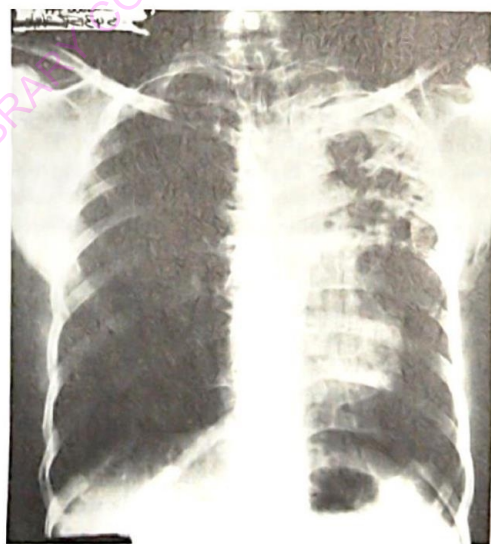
Pre-operative chest radiograph showing chronic tuberculous disease in the left upper lobe. Note the apical pleural thickening, multiple cavities and elevated hilum.
